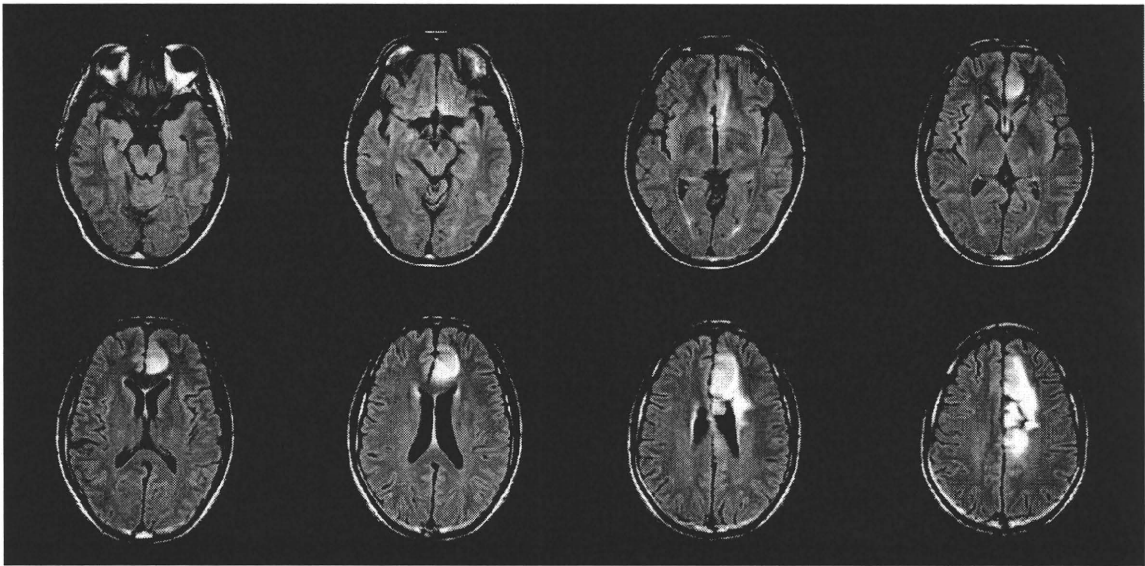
Transverse MRI with FLAIR acquisition of TO's brain. Left sides of images correspond to right side of the brain.
